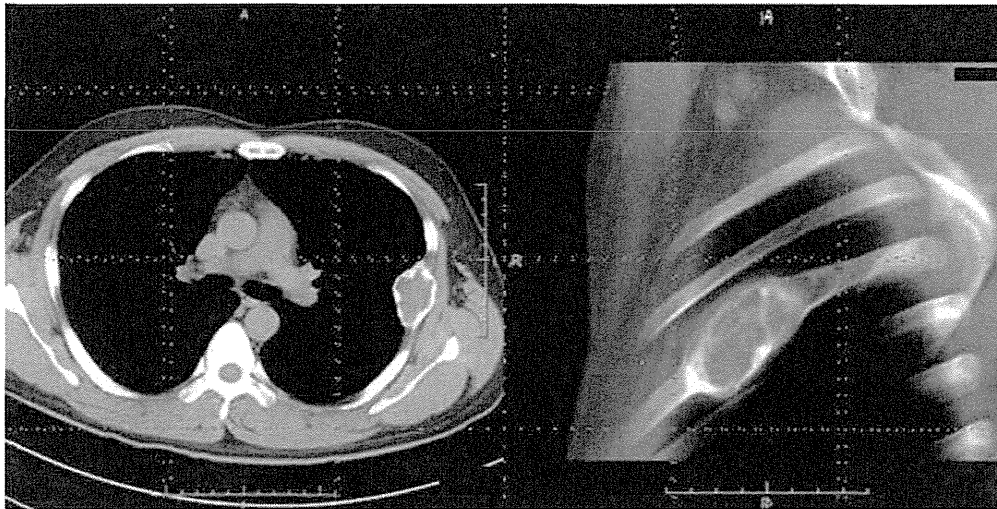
Chest CT suggested a tumor of the left fifth rib, which was surrounded with a thin bone cortex.
